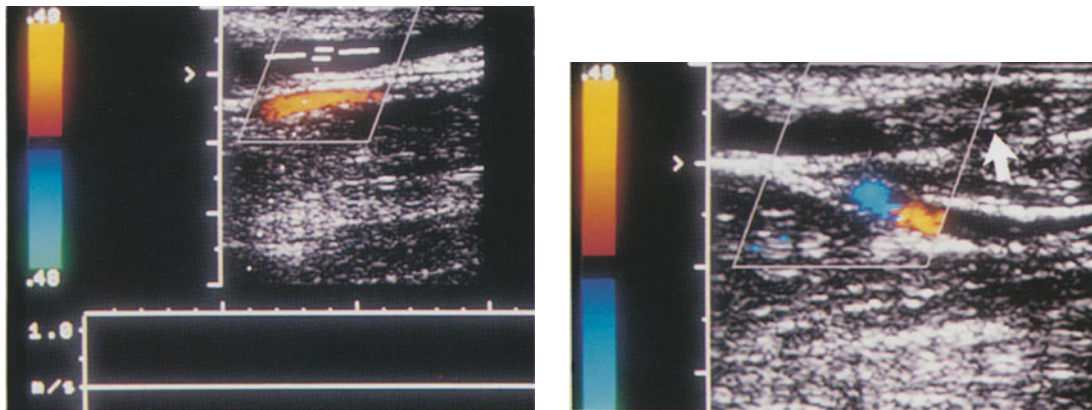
(left) Recent thrombosis of the venous limb of a dialysis fistula: the vessel lumen is anechoic and no color-coding of the lumen is present; no Doppler spectrum can be recorded from the vein. Deep to the vein, the radial artery is seen (red)
